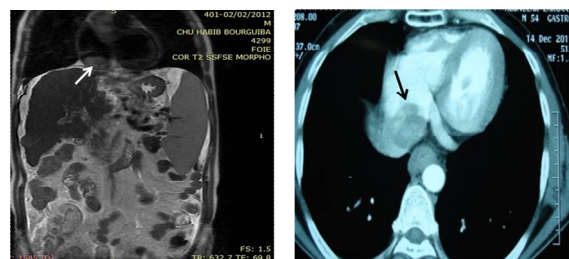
Chest computed tomography (CT) and abdominal MRI showed a tumor thrombus extending through the right hepatic vein and inferior vena cava into the right atrium.
